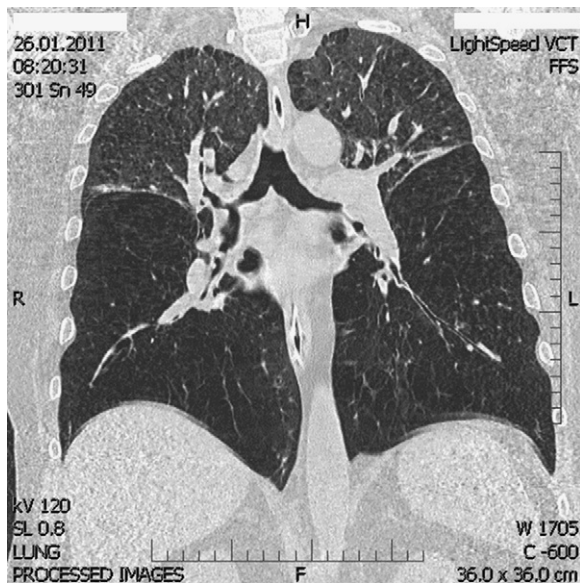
Pre-procedure CT.
